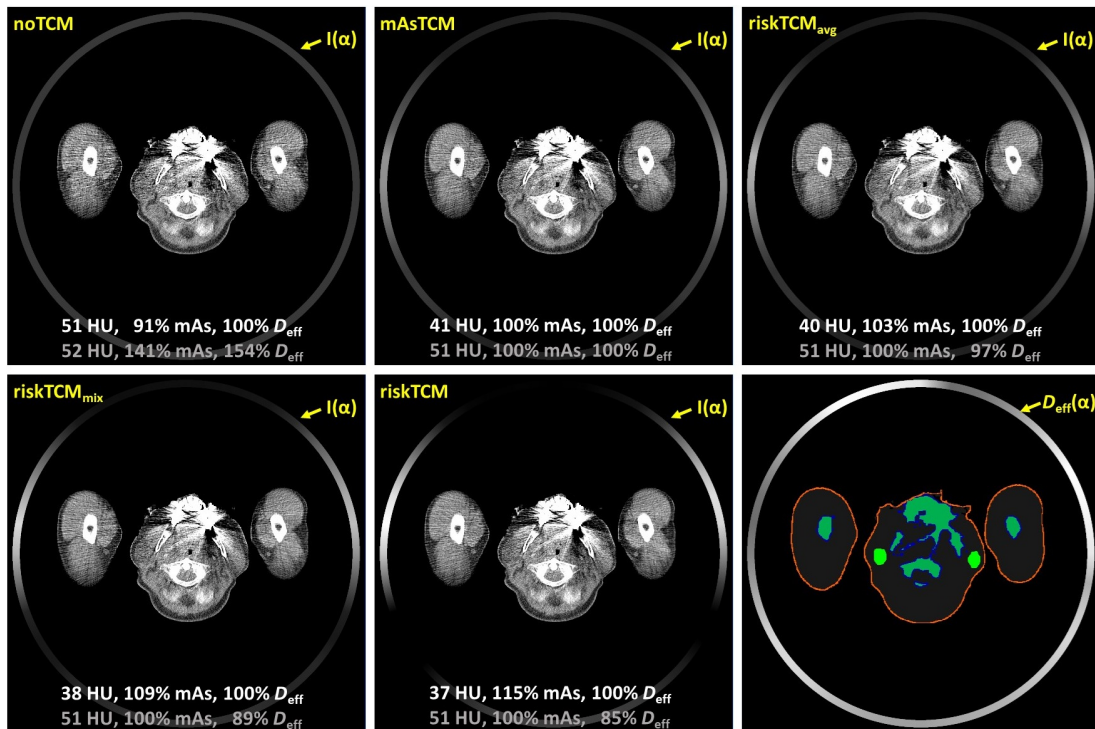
noTCM, mAsTCM, riskTCM_{avg}, riskTCM_{mix} and riskTCM images ($C = 25$ HU, $W = 400$ HU) as well as the segmented organs for an exemplary head examination with arms placed next to the head. In section 3.2.3 it is explained which colors are assigned to which organs. The circular density plots circumscribing the 50 cm FOM indicate the tube current curves $I(\alpha)$ for the CT images and the effective dose curve at constant tube current $D_{\text{eff}}(\alpha)$ for the segmented organ image. The images are shown at constant effective dose (100% D_{eff}). Image noise values as well as mAs integrals are given in the upper of the two rows in white. In addition, the numerical evaluation is given for the case of constant image noise in the lower rows in gray.
